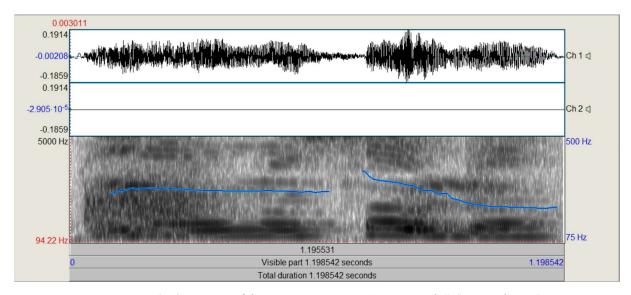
Sonogram of the Porteño utterance "Veo uno solo" ('I see only one')
